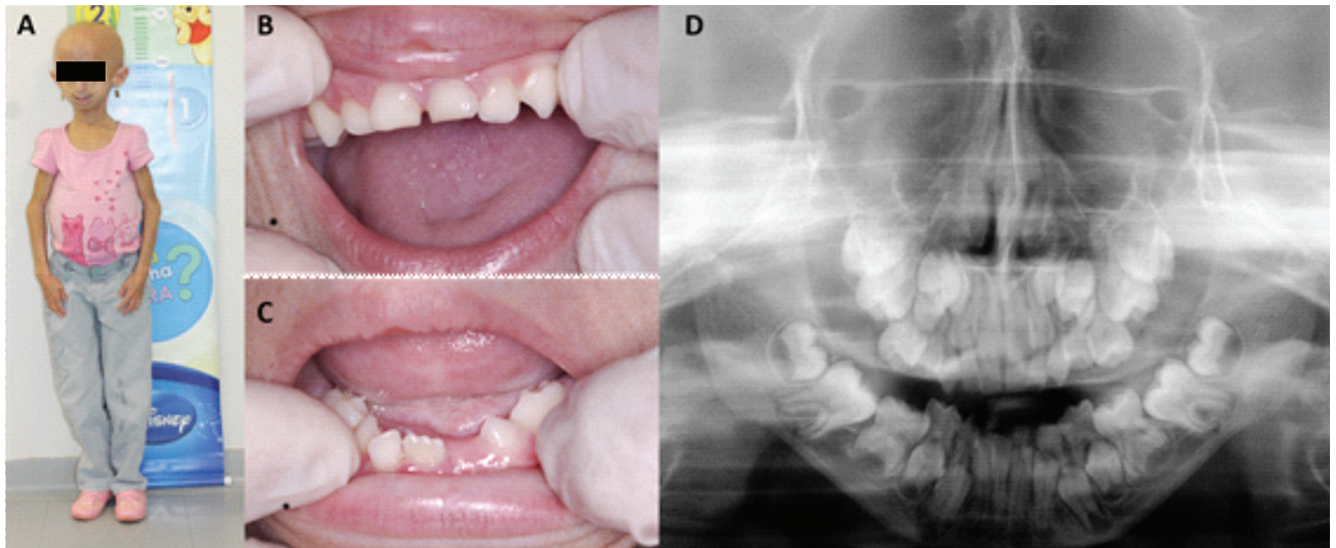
A) Aged clinical appearance and short stature at 6 years of age. B) Limited mouth opening. C) Dental crowding in anteroinferior region. D) Initial panoramic radiograph.
